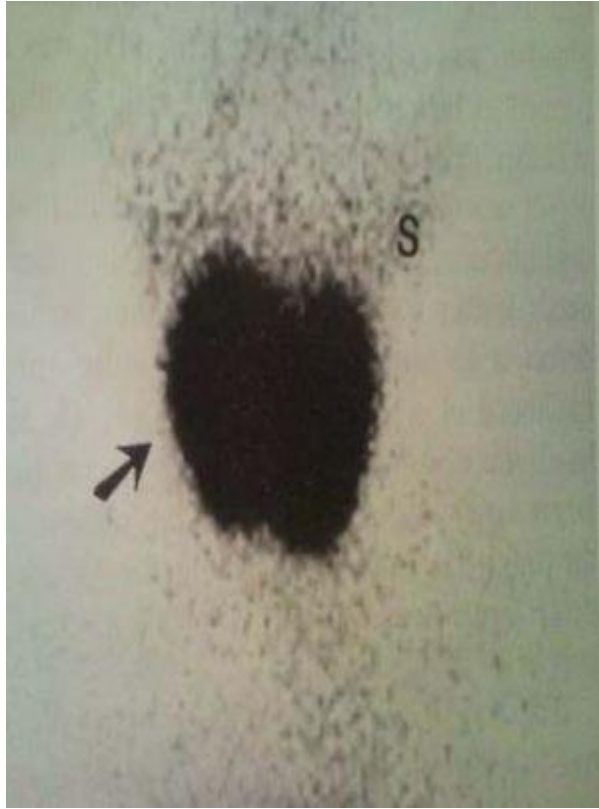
<sup>99m</sup>Tc pertechnetate thyroid scintigraphy re-vealing a eutopic enlarged gland (arrow) which is showing increased uptake, (s) salivary gland.
